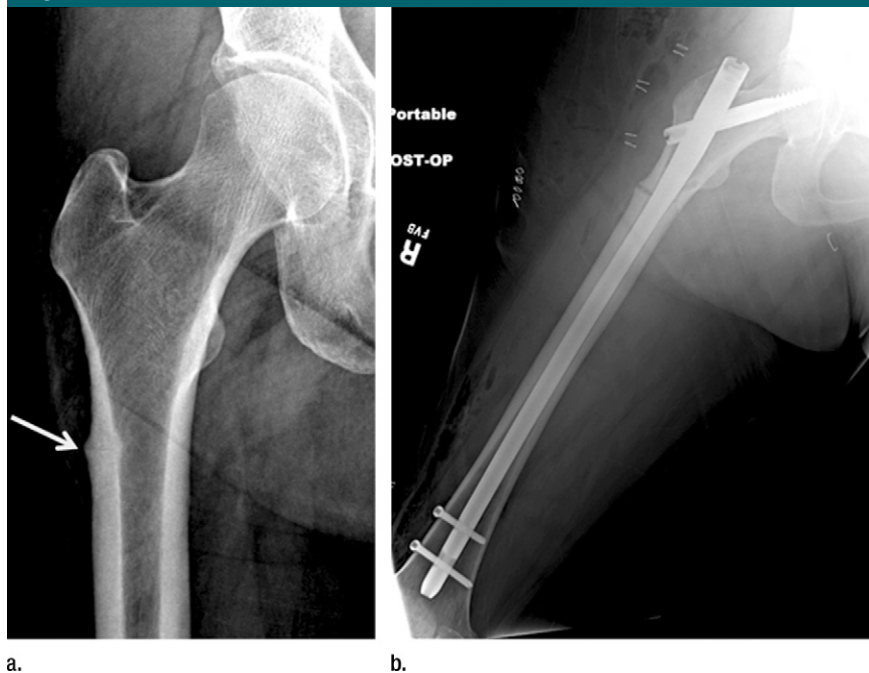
Radiographs show atypical subtrochanteric stress fracture of the right proximal femur diaphysis in a 65-year-old woman who underwent treatment for 5 years with alendronate. (a) Note the focal periosteal reaction with cortical thickening of the right lateral femoral diaphysis with subtle fracture line (arrow). (b) Image demonstrates protective internal fixation of the fracture with a long gamma nail.
